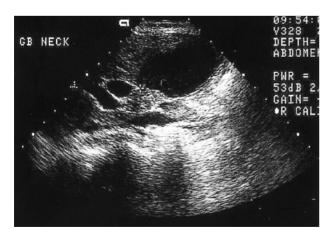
Ultrasonography of the gallbladder reveals a segmental wall thickening of the neck portion, subsequently proven to be a carcinoma.
